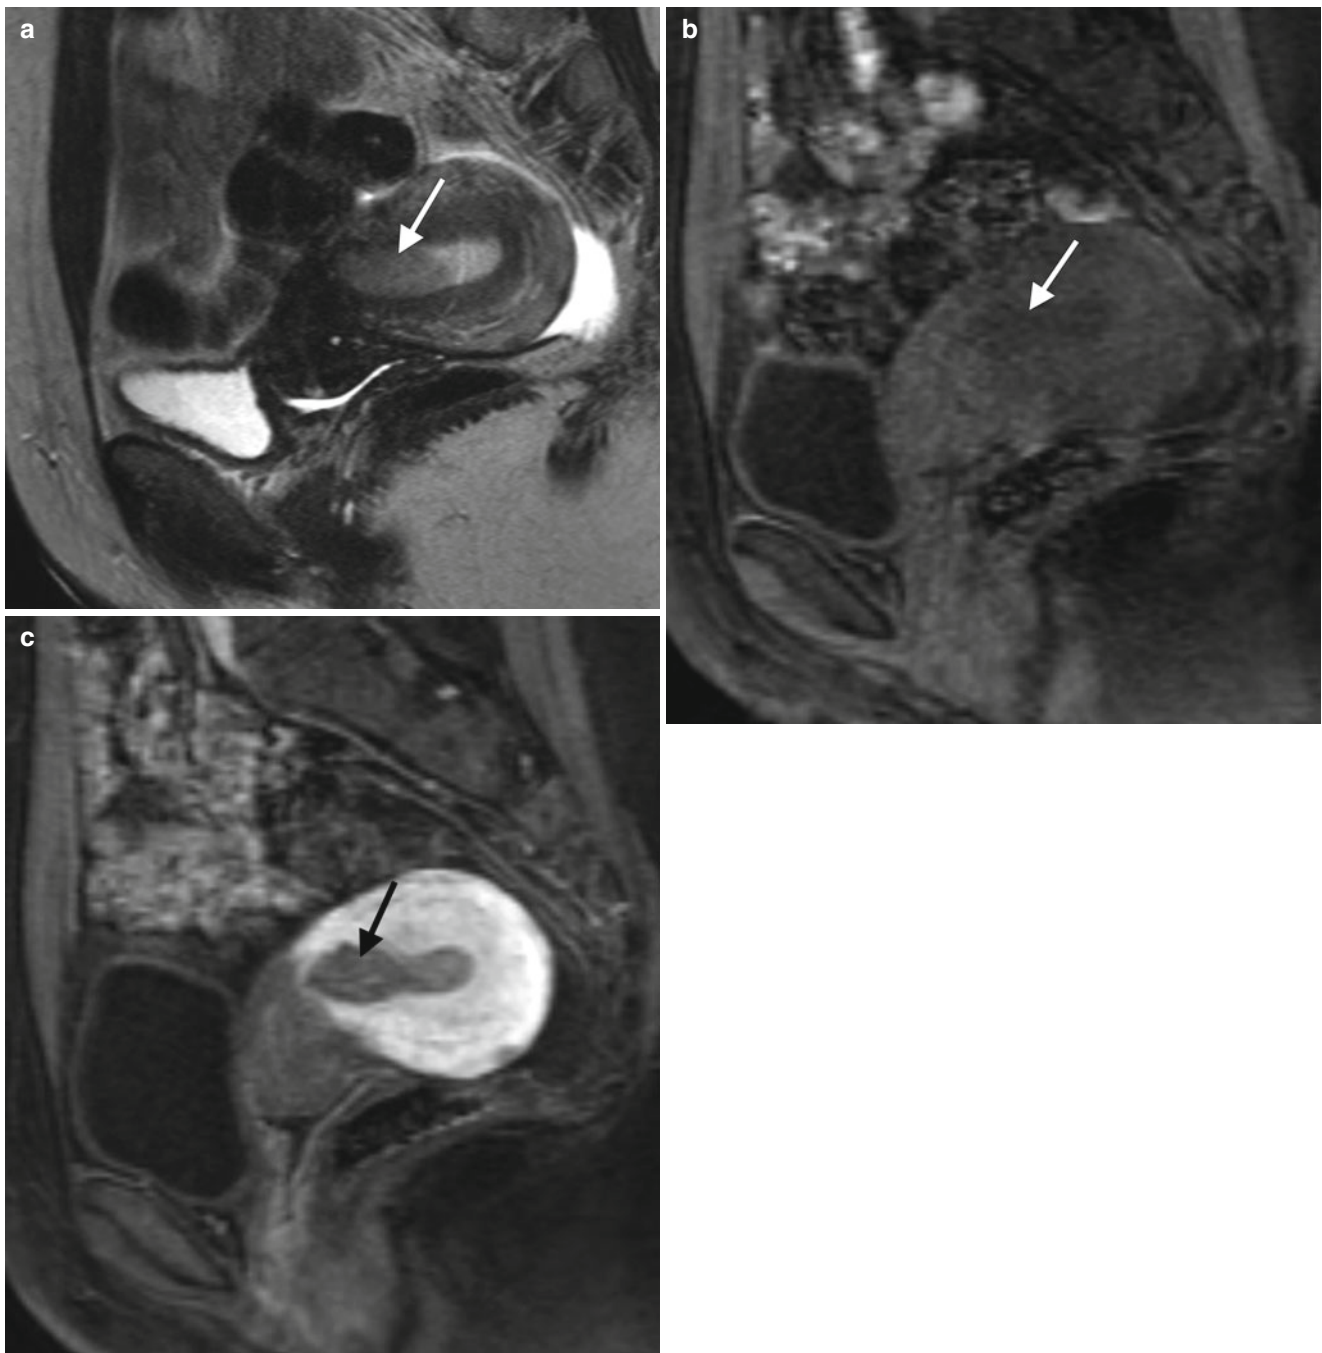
FIGO stage IA endometrial cancer in a 37-year-old woman with vaginal bleeding between menstrual periods. A sagittal T2-weighted MR image (a) and fat-suppressed sagittal T1-weighted images before (b) and after (c) intravenous gadolinium demonstrate
